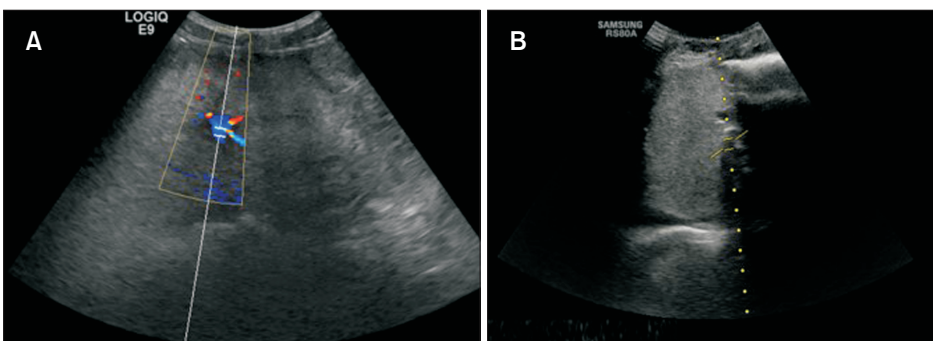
(A) Preoperative abdominal ultrasonography (USG) showed patent left portal vein (LPV) near the Rex recess; however, the peak systolic velocity (PSV) was reduced to 11.1 cm/s, and the flow direction was reversed. (B) Postoperative USG showed patent LPV and the PSV improved to 34.3 cm/s.
